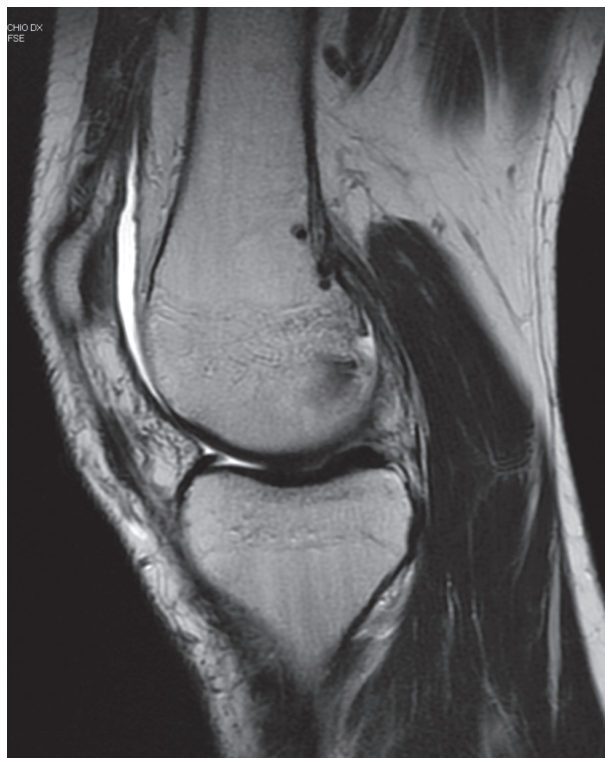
MRI T2 image shows the extremely posterior position of femoral tunnels
